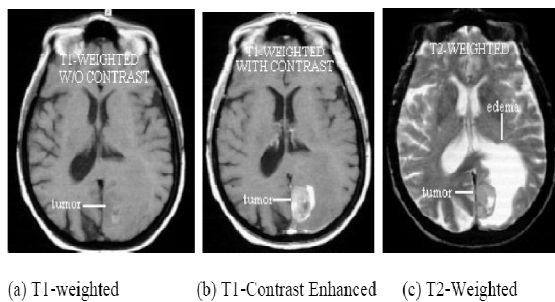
Appearance of tumor in T1-weighted, T1-contrast enhanced and T2-weighted images of the same axial slice
